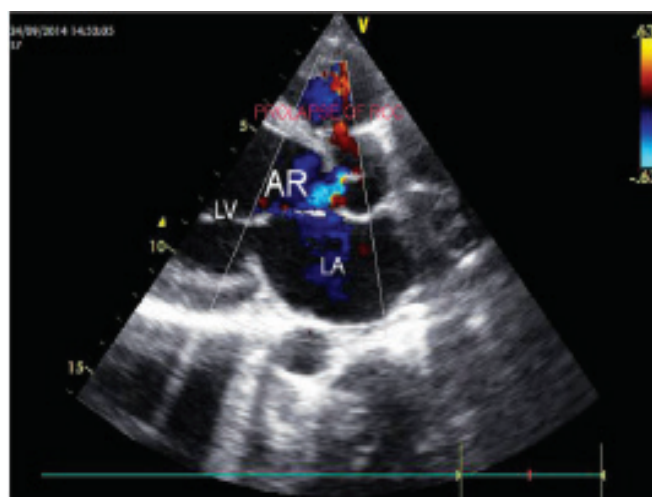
Parasternal long axis view - showing the mild AR with prolapsed of RCC through VSD
